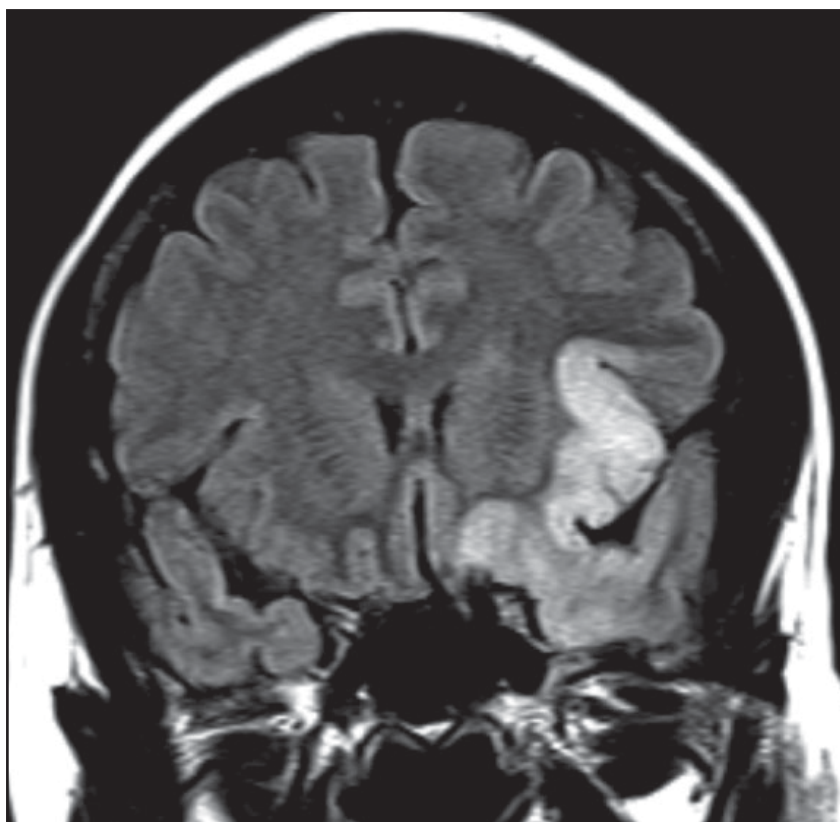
Coronal FLAIR (fluid-attenuated inversion recovery) image demonstrates abnormal hyperintense signal and gyral swelling involving the left insula, mesial temporal lobe, and inferior frontal lobe.
